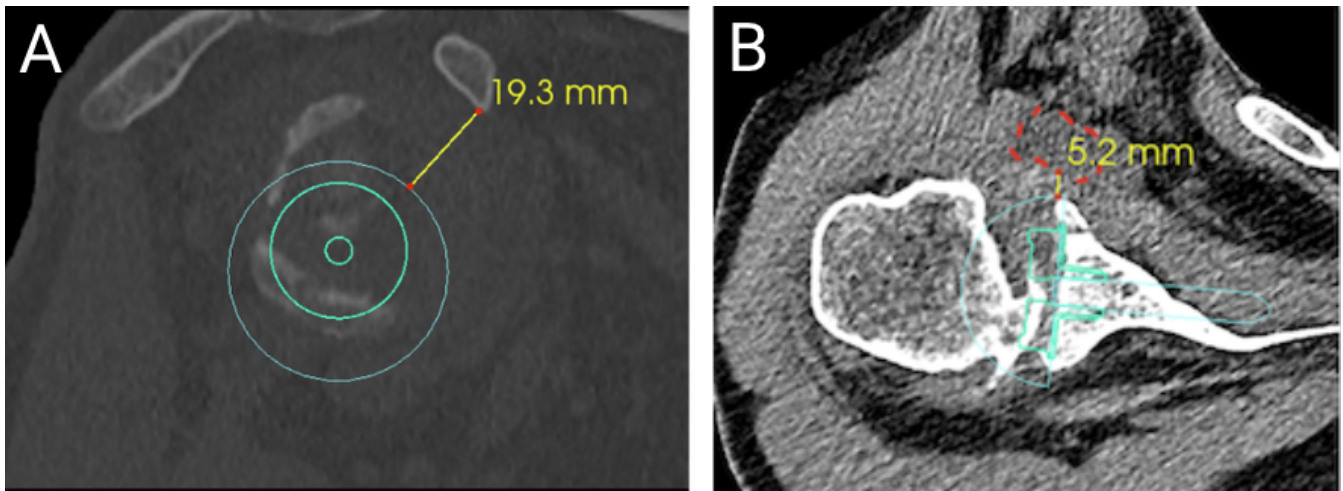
(A) This screenshot shows the CT scan slice where the peripheral margin of the glenosphere just appeared as a full circle, scrolling in sagittal plain from medial to lateral, on bone sequences from the CT scan uploaded to a software (Imascap, Brest, France). The distance between the coracoid's inferior pole and the peripheral margin of the glenosphere is then measured. (B) This screenshot shows the CT scan slice, axial plain, soft-tissue sequences, passing through the middle of the central baseplate's peg, where it has the biggest shape, from the CT scan uploaded to a software (Imascap, Brest, France). The red dashed line represents the conjoint tendon in cross-section. The distance between the conjoint tendon and the peripheral margin of the glenosphere is then measured.
